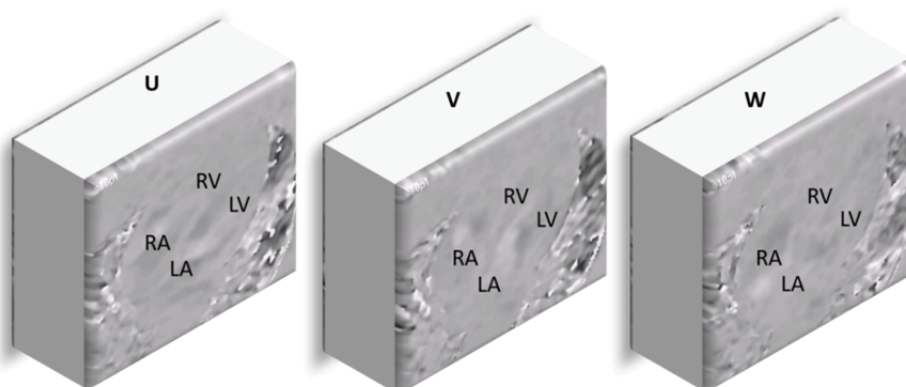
Example of reconstructed whole-heart 4D Flow MRI volumes of the three velocity components (the in-plane \mathbf{U} , \mathbf{V} components and the through-plane \mathbf{W} component). Grey-scale values encode the velocity magnitude and direction along the direction of interest.
